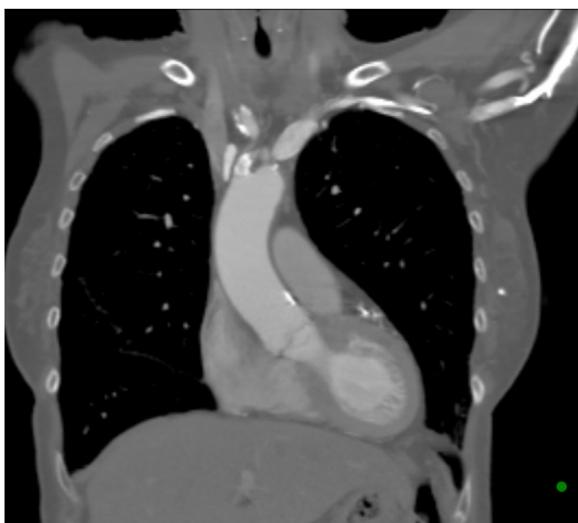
Coronal section from computed tomography demonstrating severe occlusive atherosclerotic disease at the origin of the innominate artery.
